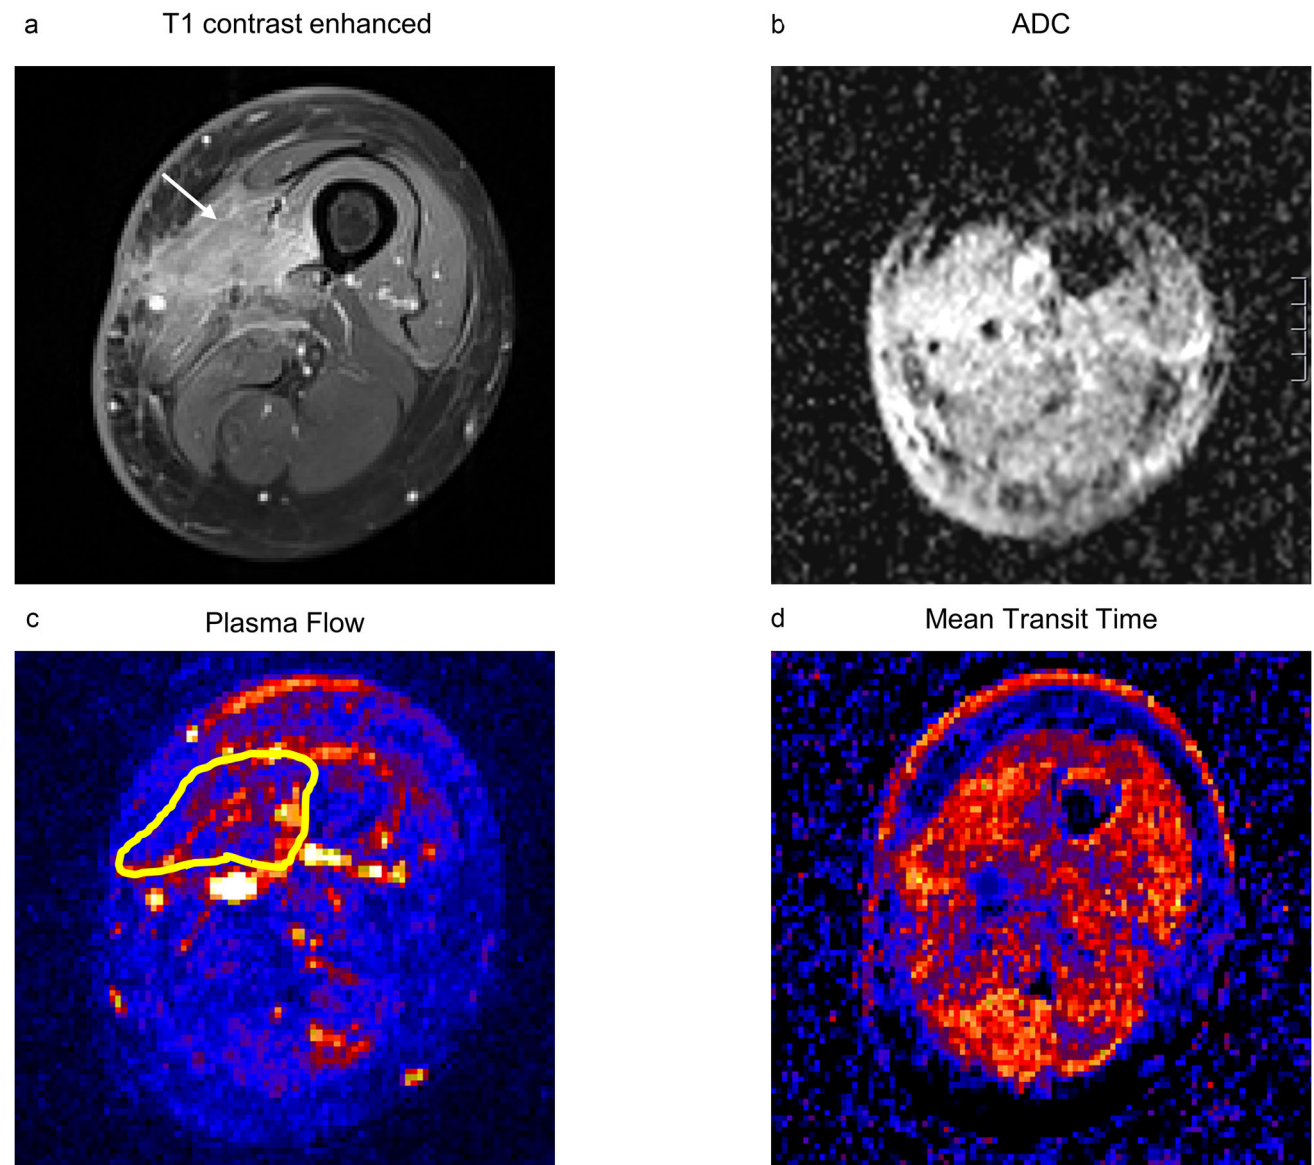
Regular postoperative situs of the thigh of a 52-year-old woman after excision of pleomorphic sarcoma. No Recurrence was detected in routine follow-up 6 months later. (a) Contrast-enhanced T1-weighted image. White arrow shows slight enhancement. (b) ADC-map. (c) Plasma flow map. PF is minimally increased in the area of surgery compared to surrounding tissue. (d) Mean transit time map. It shows no relevant change in the area of surgery compared to surrounding tissue.
